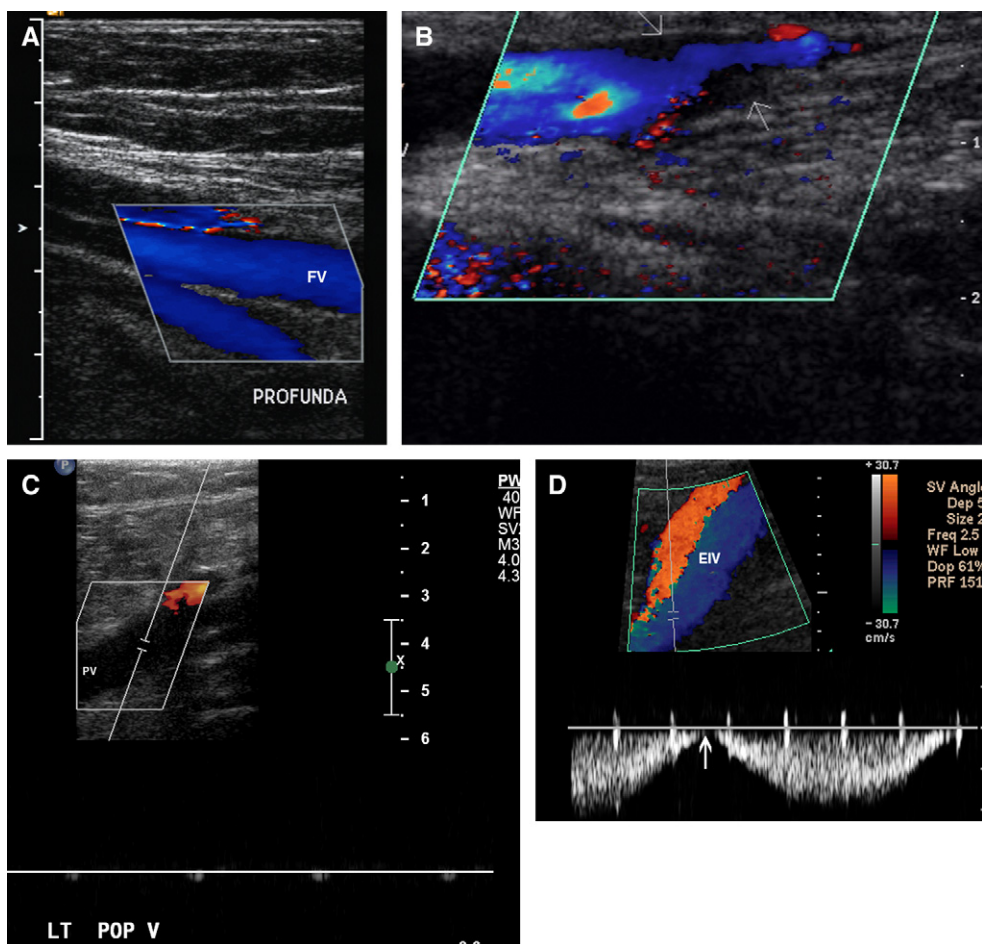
(A) Normal veins demonstrating color flow filling the entire vessel lumen. FV, femoral vein. (B) Partial venous thrombosis demonstrating focal absence of color flow (arrows). (C) Occlusive venous thrombosis demonstrating complete absence of color flow in the popliteal vein. Also note absence of venous waveform on duplex spectrum. (D) Normal respiratory phasicity of the right iliac vein. Note return of flow to baseline during inspiration (arrow). (E) Augmentation maneuver demonstrates surge of flow in right popliteal vein when squeezing the calf (arrow). (F) Normal color flow Doppler appearance of the junction of the greater saphenous vein (GSV) and the common femoral vein (CFV). (G) Thrombosis of the left greater saphenous vein (GSV) near the junction with the common femoral vein (arrow). (H) Six days later the greater saphenous vein thrombosis has extended into the common femoral vein (V) as demonstrated on the transverse compression images.
